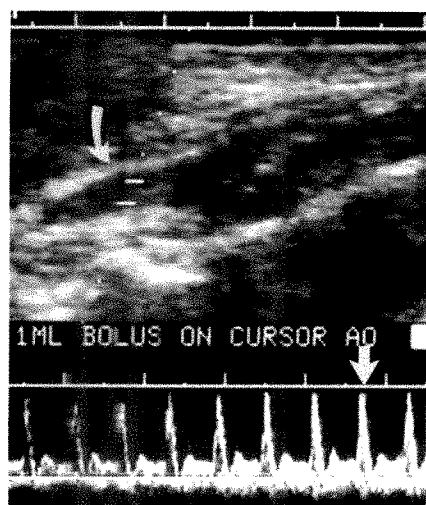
Duplex sonogram oblique to abdominal aorta (curved arrow) shows effect of 0.1 ml of microspheres on aortic Doppler signal. Note increased brightness of velocity waveform when microspheres reach sampling volume. Peak effect (straight arrow) was at 3 sec after onset. Brightness returned to baseline 8 sec after onset (not shown).
